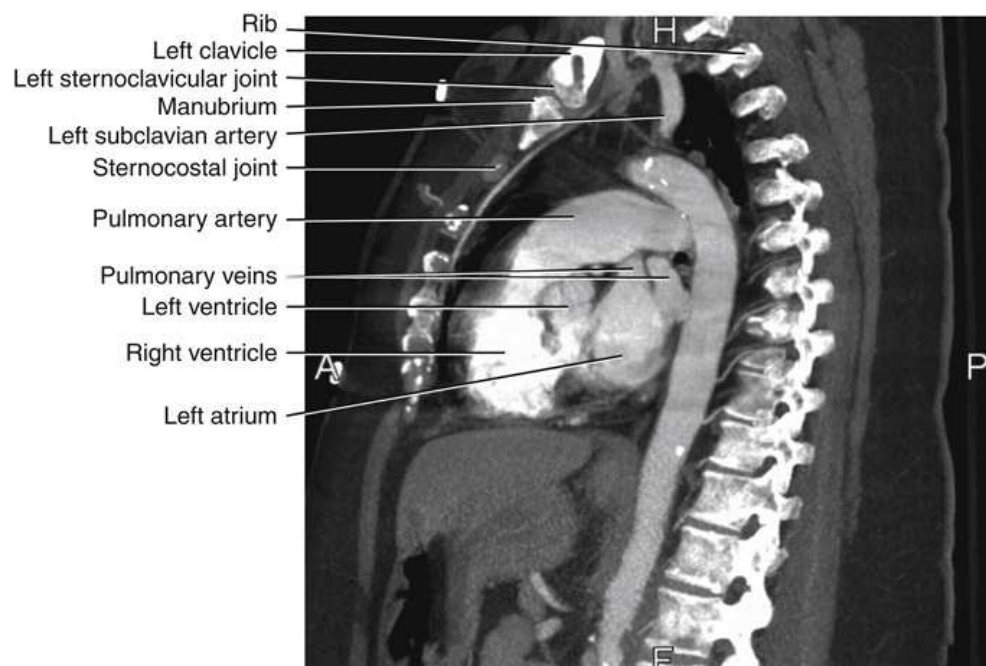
Sagittal CT image of thorax corresponding to level *C* in Fig. 24.39.
